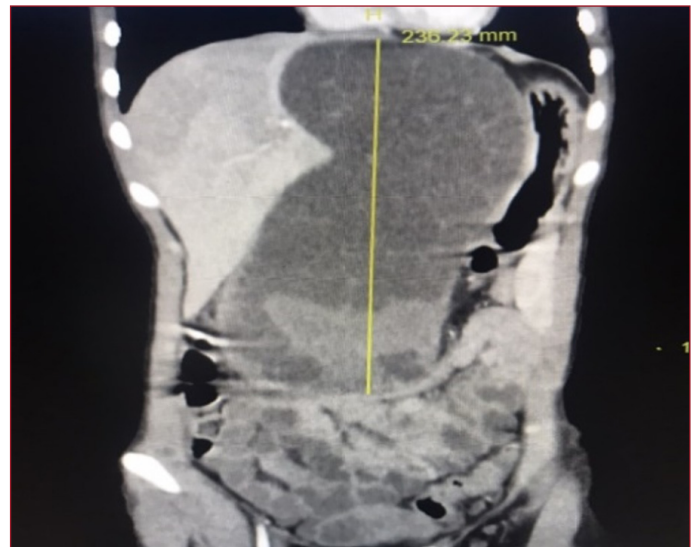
CT image of the lesion
